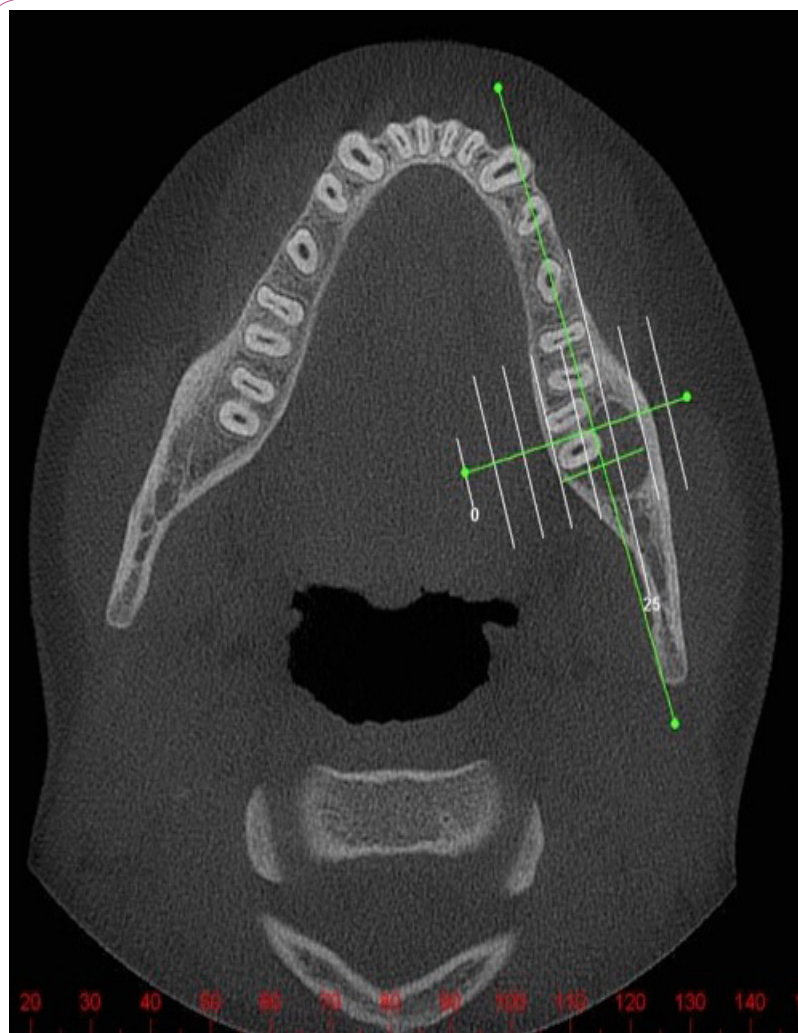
Axial cut of CBCT tooth 37 showing bucco-distal extension of radiolucency.
